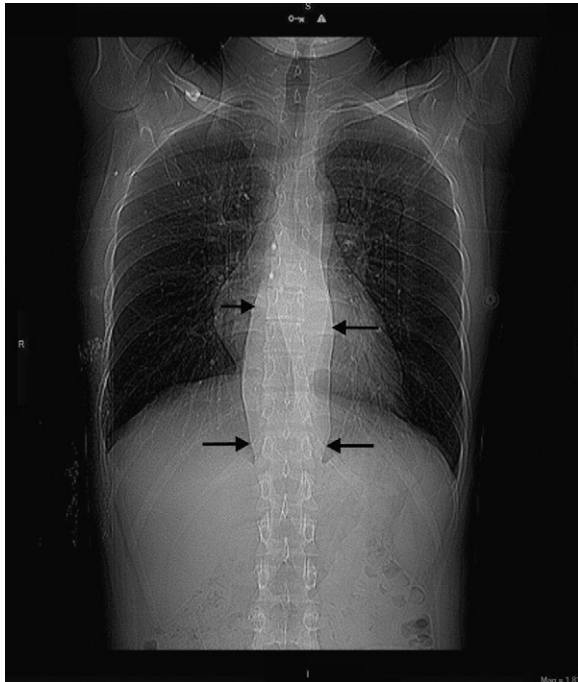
Computerized tomography (CT) imagination of Pott's abscess.
